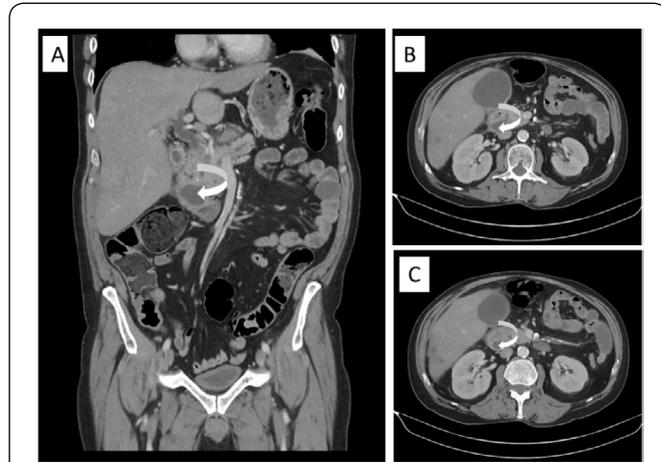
A coronal and axial CT abdomen and pelvis showing pancreatic head cystic lobulated mass, with a tiny focus of calcification. There is also mild stranding along the lateral border of the second part of the duodenum which may be related to grove pancreatitis as indicated by the white arrow.
